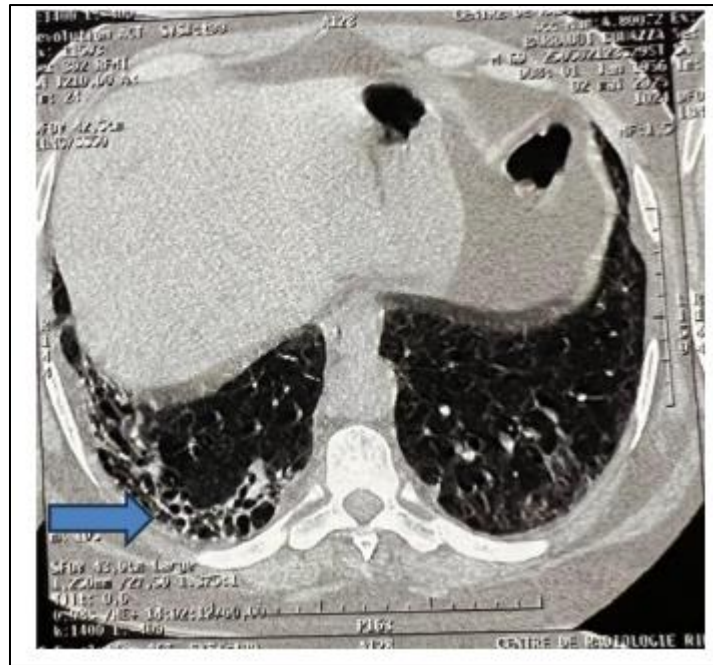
High-resolution chest CT (HRCT) scan demonstrating advanced fibrotic patterns with characteristic honeycombing and traction bronchiectasis
